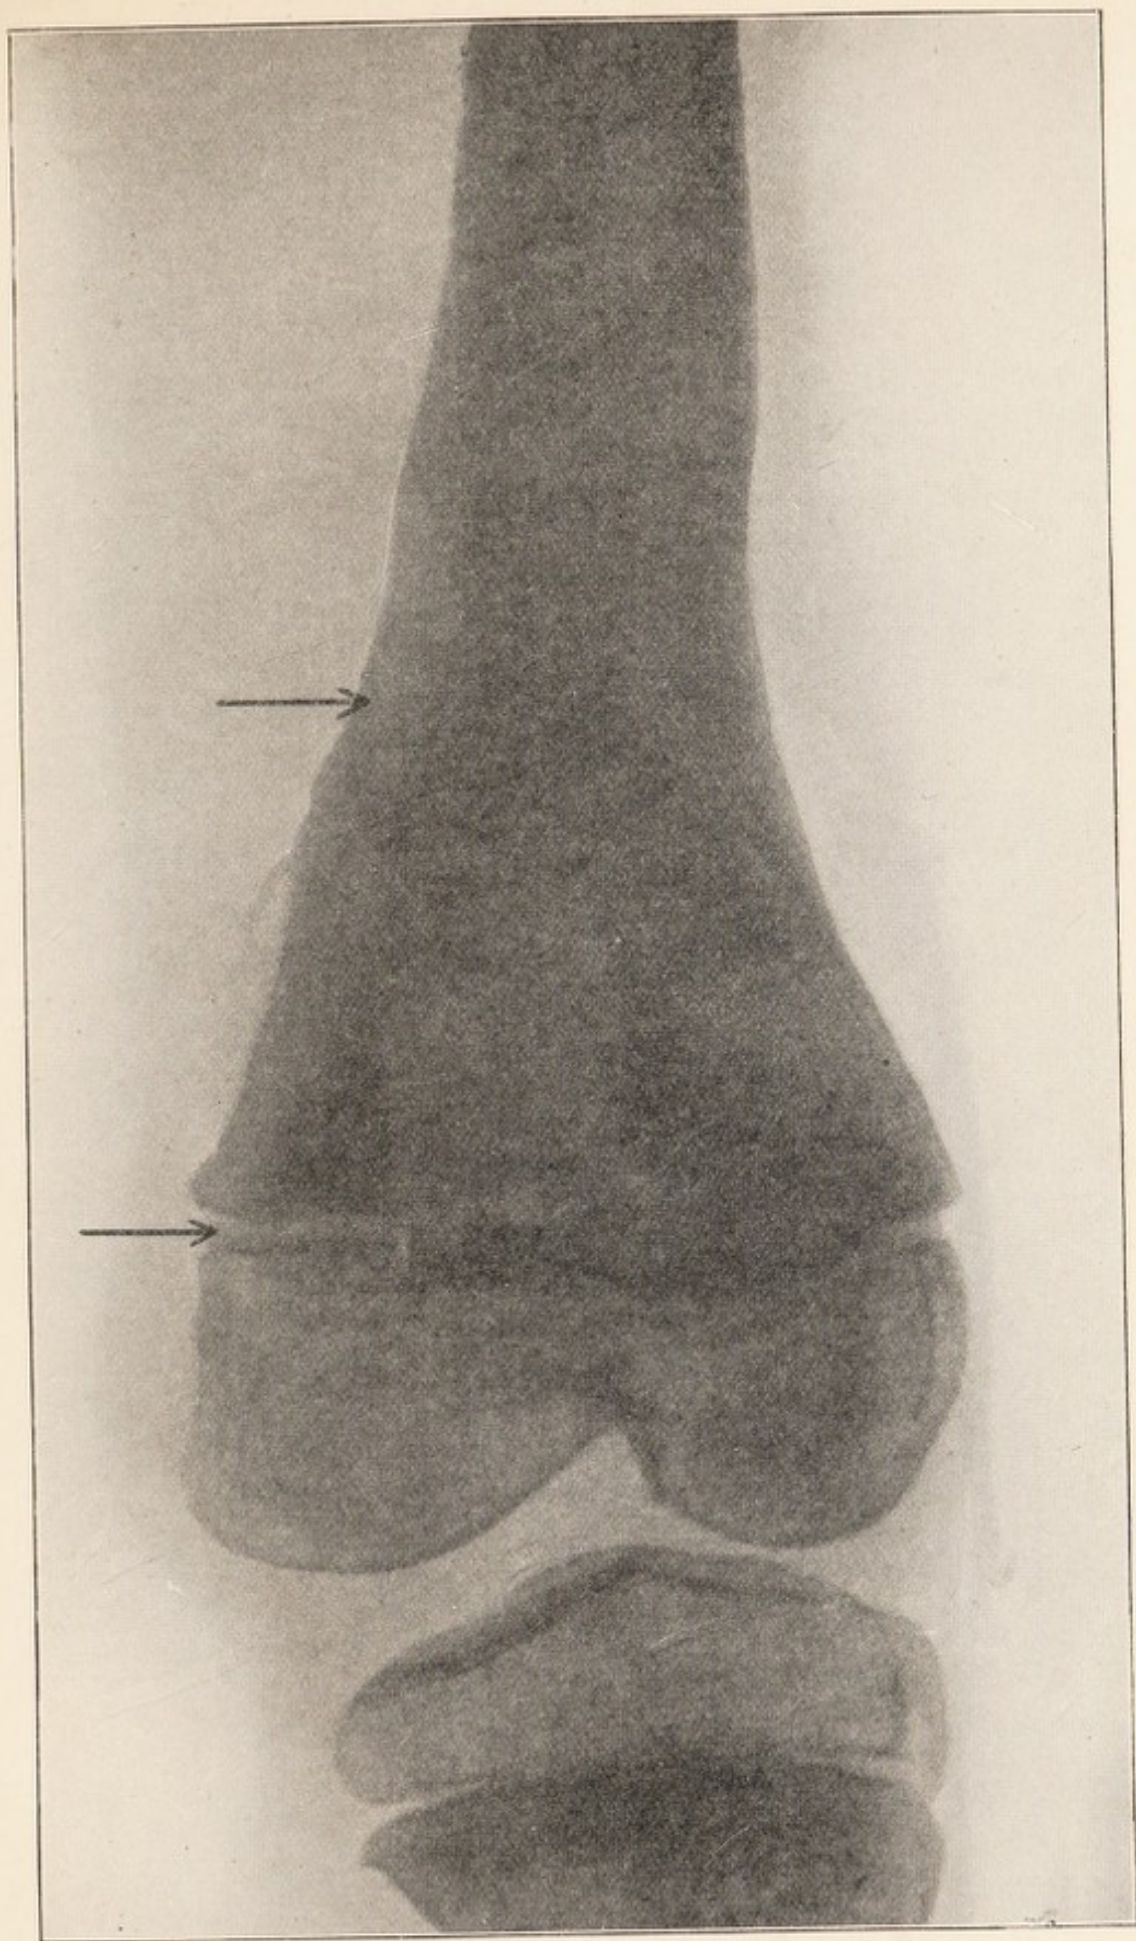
X-ray of second case, one year after operation. (The bone removed is shown in Fig. 69, and the new bone lies between the arrows.)
